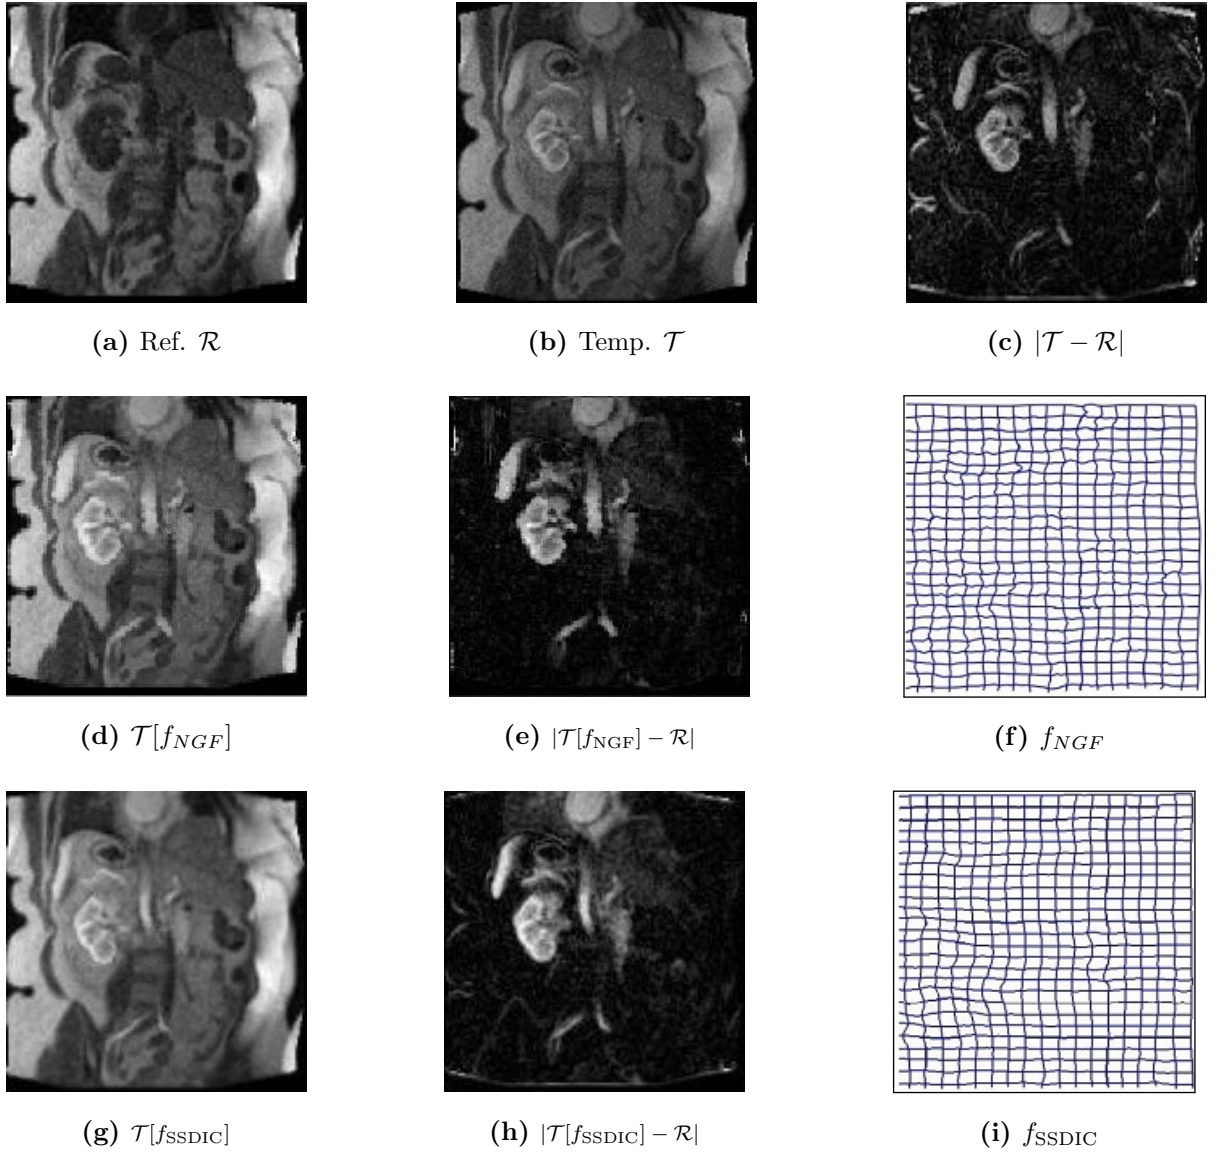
Results of pairwise registration of DCE-MR images. (a) reference, (b) template image, (c) difference image between the template and reference, (d) and (g) are the transformed templates, (e) and (h) are the difference images between the transformed template and the reference image, (f) and (i) are the optimal transformations aligning the template to the reference image using different distance measures.
